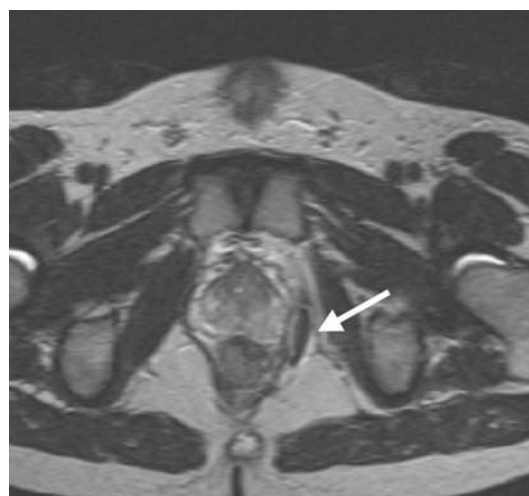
The same patient as presented in Figure 4. Axial T2 weighted MR image shows hypointense structure being gas (*arrow*) in a fistula's track in the left ischioanal fossa.
